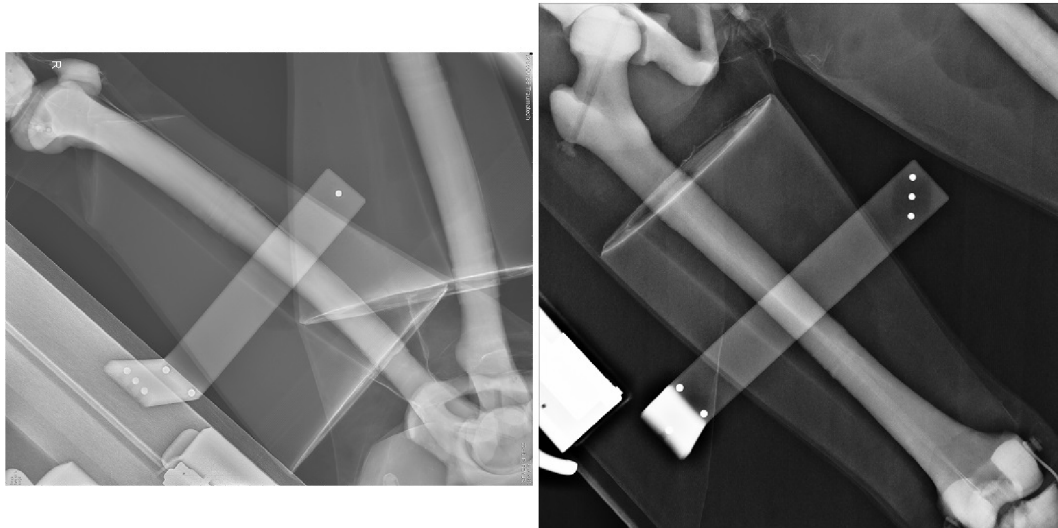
Radiographs captured using L-shaped calibration marker shown in Figure F.1 (left).
